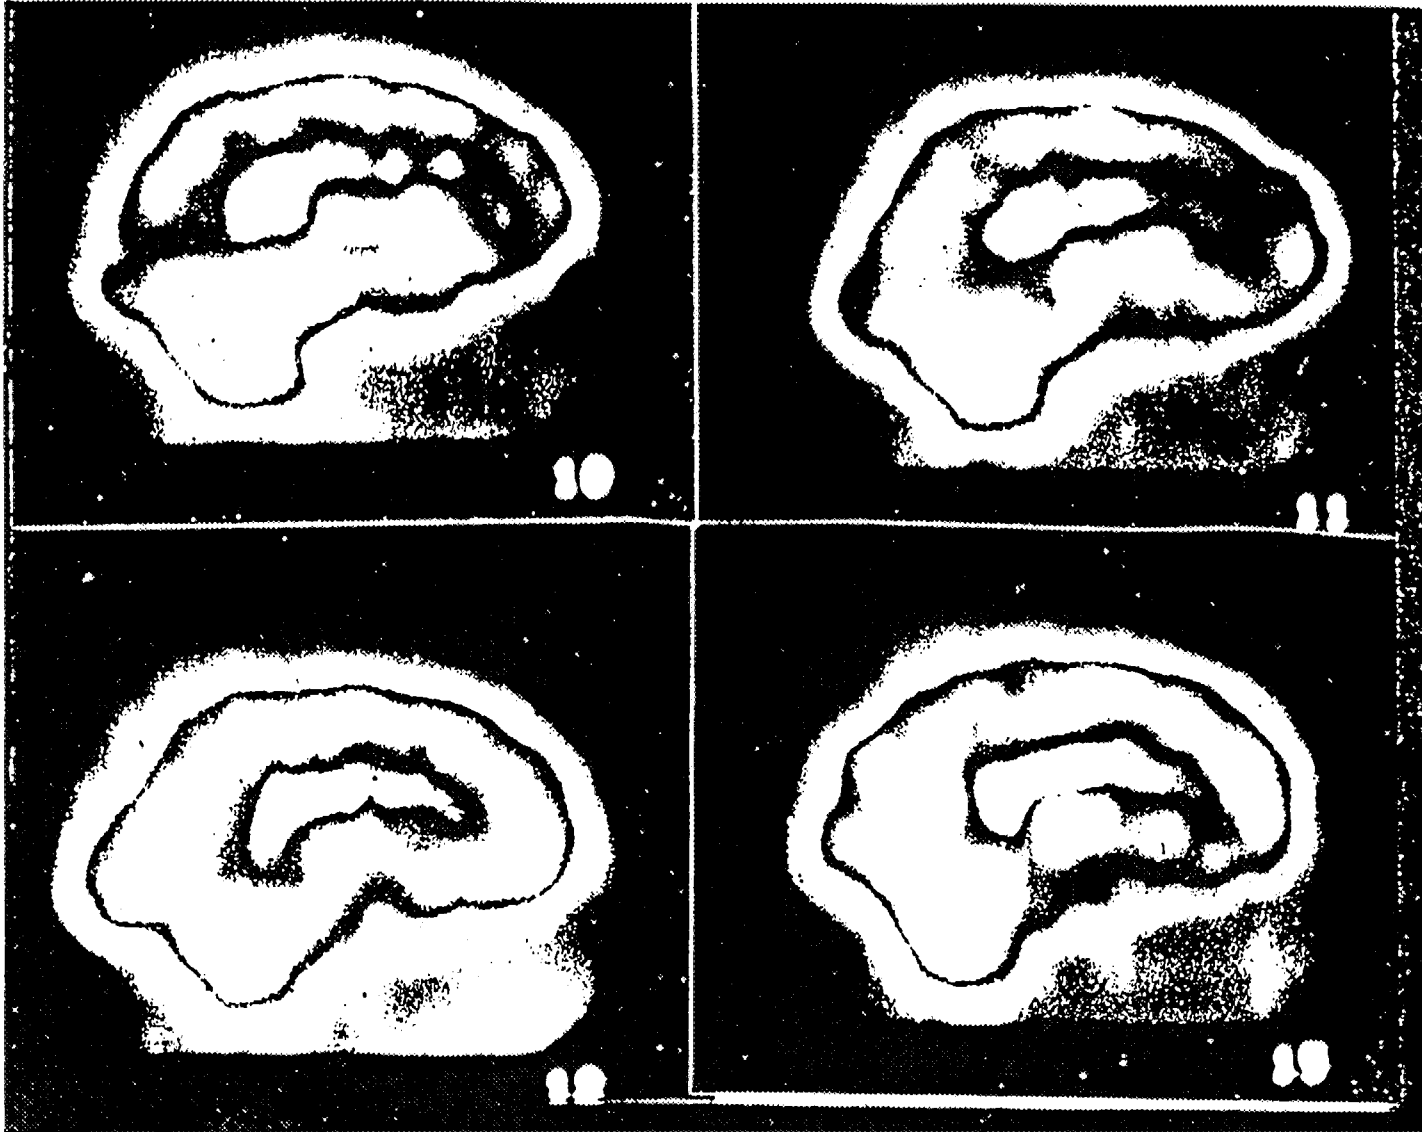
C. shows normal HMPAO ^{99m}Tc SPECT STUDY in Sagittal sections. Note homogenous distribution of ^{99m}Tc HMPAO, and separation of grey matter and white matter perfusion.
